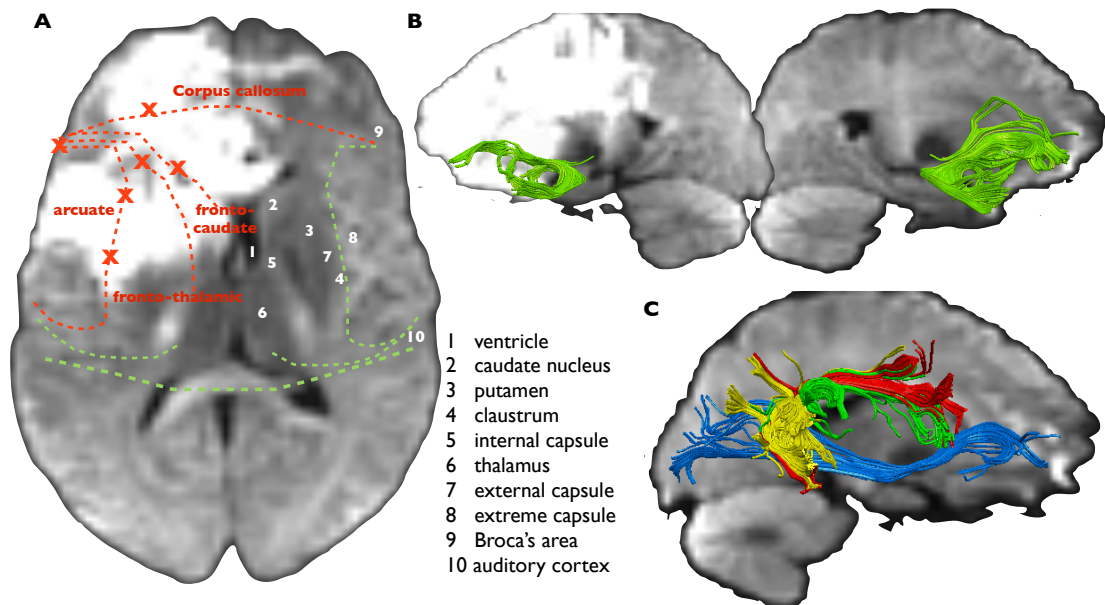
DWI Damage patient 02 and white matter connections
